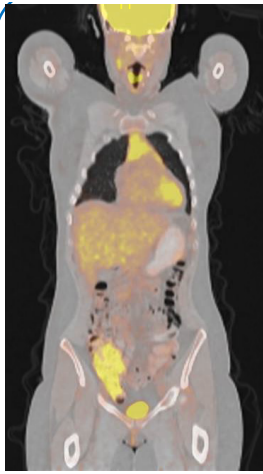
Recurrent disease read as mild to moderate uptake in the lymph nodes of the neck on PET/CT
